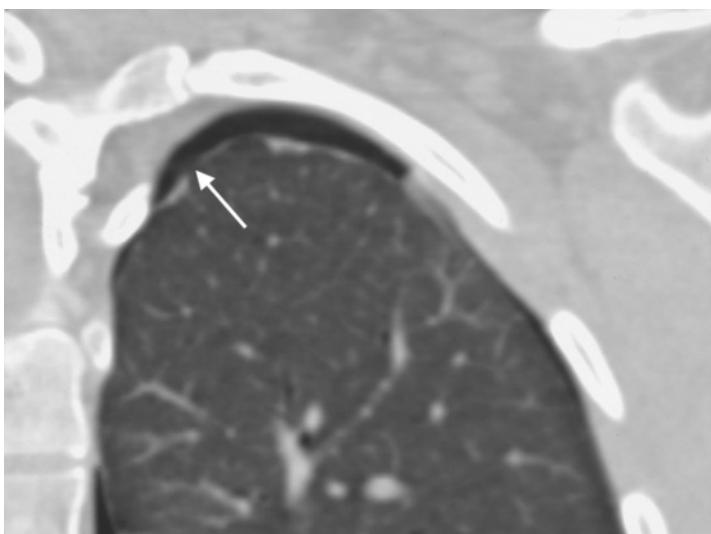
CT image of the visceral pleura in pneumothorax. Discrete thickening of the visceral pleura in spontaneous apical pneumothorax. Tiny subpleural bullae (white arrow).
